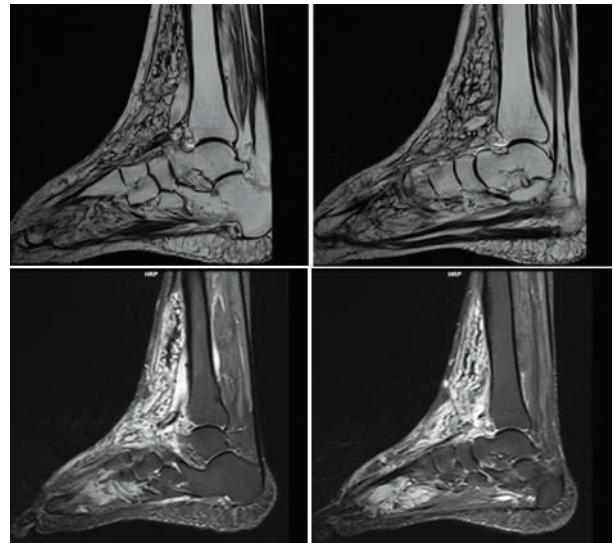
Magnetic Resonance Imaging (MRI) showing evidence of vascular malformation and no features of mycetoma.
